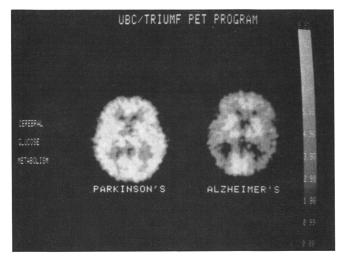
Fluorodeoxyglucose (FDG) PET scans of patients with Parkinson's disease and Alzheimer's disease. The Parkinson scan is normal (see figure 2 for comparison) but in the Alzheimer scan, there is hypometabolism in temporoparietal cortex, with preservation of subcortical structures and occipital cortex.
